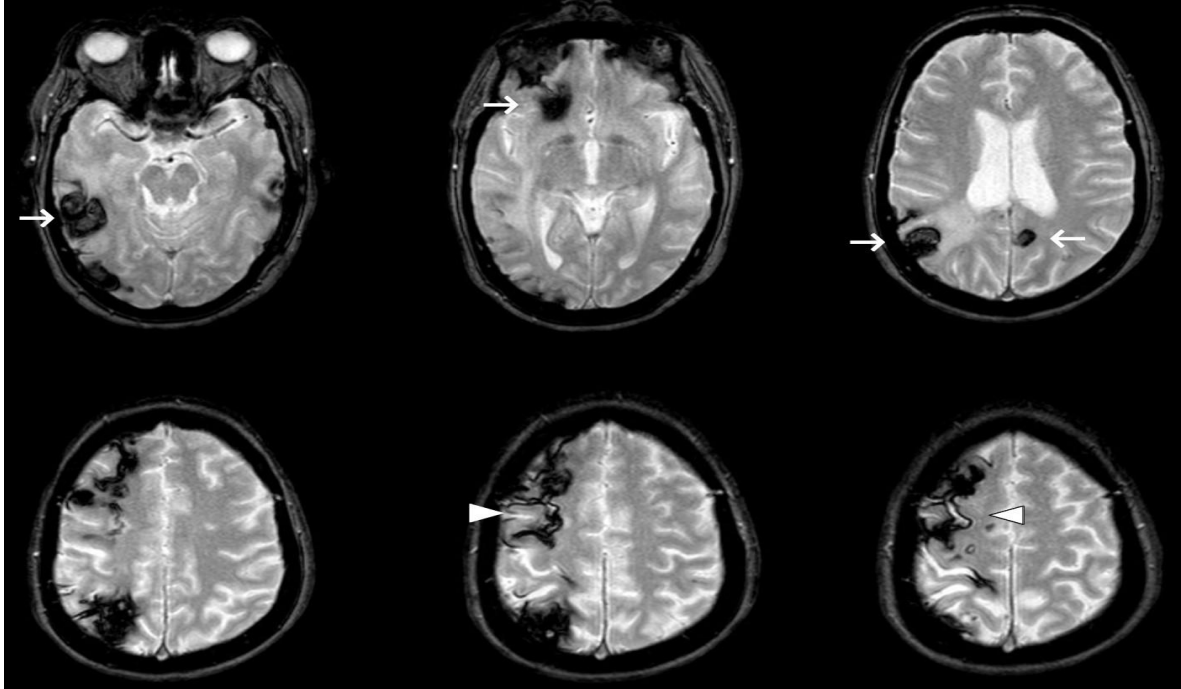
MRI images in axial T2*/GRE sequence demonstrating multiple cavernomas (white arrows), with heterogeneous signal intensity showing "blooming" effect and, associated with subarachnoid hemorrhages of the convexity (white arrowhead) .
